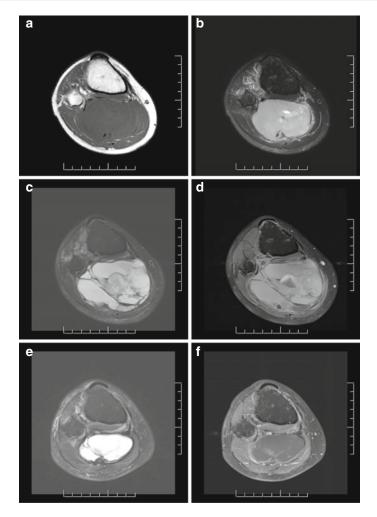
A 28-year-old male with synovial sarcoma in the proximal calf/popliteal fossa. At diagnosis, (a) axial T1-weighted MRI image and (b) axial T2-weighted image with fat suppression show a large solid STS involving the superficial and deep posterior calf compartments and extending into the popliteal fossa with involvement of the neurovascular bundle. Following preoperative chemotherapy, (c) axial T2 with fat suppression and (d) axial T1 with fat suppression and gadolinium MRI images demonstrate interval enlargement and development of multiloculated cystic components with fluid levels, suggestive of hemorrhage and necrosis. Some rims of enhancement are seen
